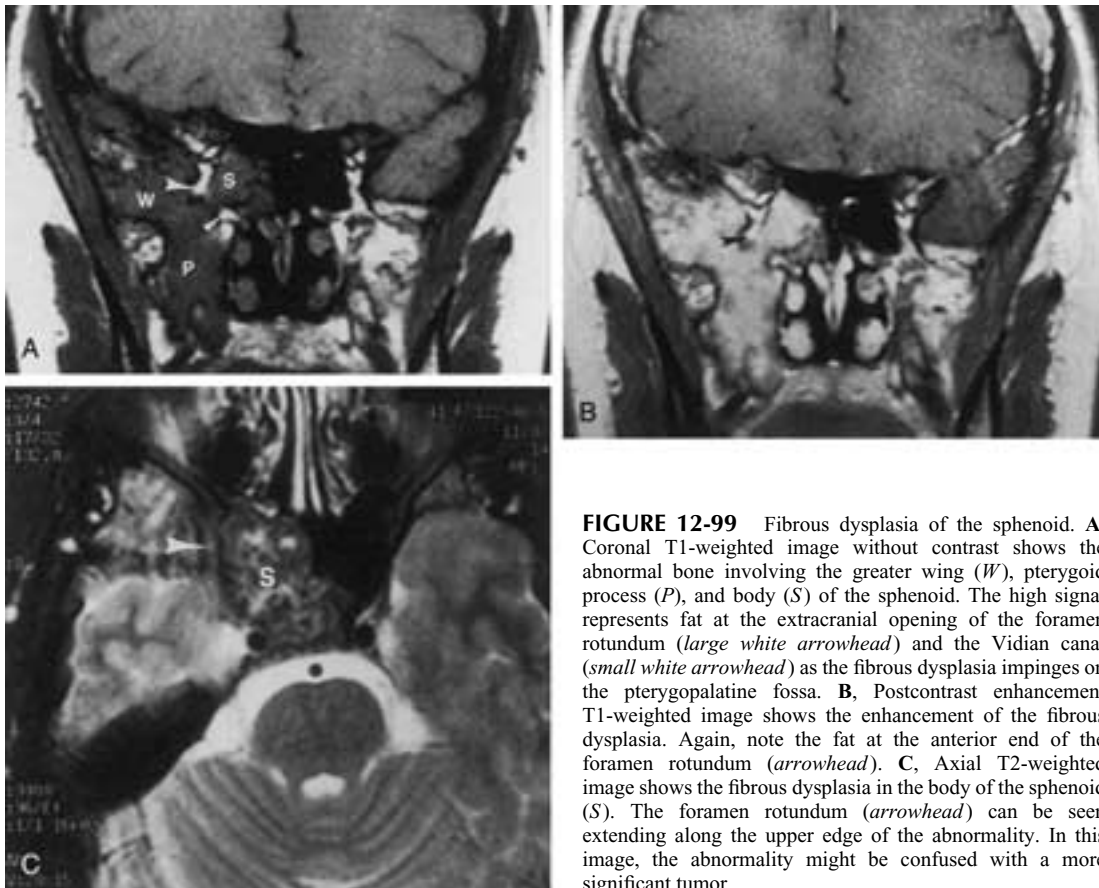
Fibrous dysplasia of the sphenoid. A, Coronal T1-weighted image without contrast shows the abnormal bone involving the greater wing (*W*), pterygoid process (*P*), and body (*S*) of the sphenoid. The high signal represents fat at the extracranial opening of the foramen rotundum (*large white arrowhead*) and the Vidian canal (*small white arrowhead*) as the fibrous dysplasia impinges on the pterygopalatine fossa. B, Postcontrast enhancement T1-weighted image shows the enhancement of the fibrous dysplasia. Again, note the fat at the anterior end of the foramen rotundum (*arrowhead*). C, Axial T2-weighted image shows the fibrous dysplasia in the body of the sphenoid (*S*). The foramen rotundum (*arrowhead*) can be seen extending along the upper edge of the abnormality. In this image, the abnormality might be confused with a more significant tumor.
